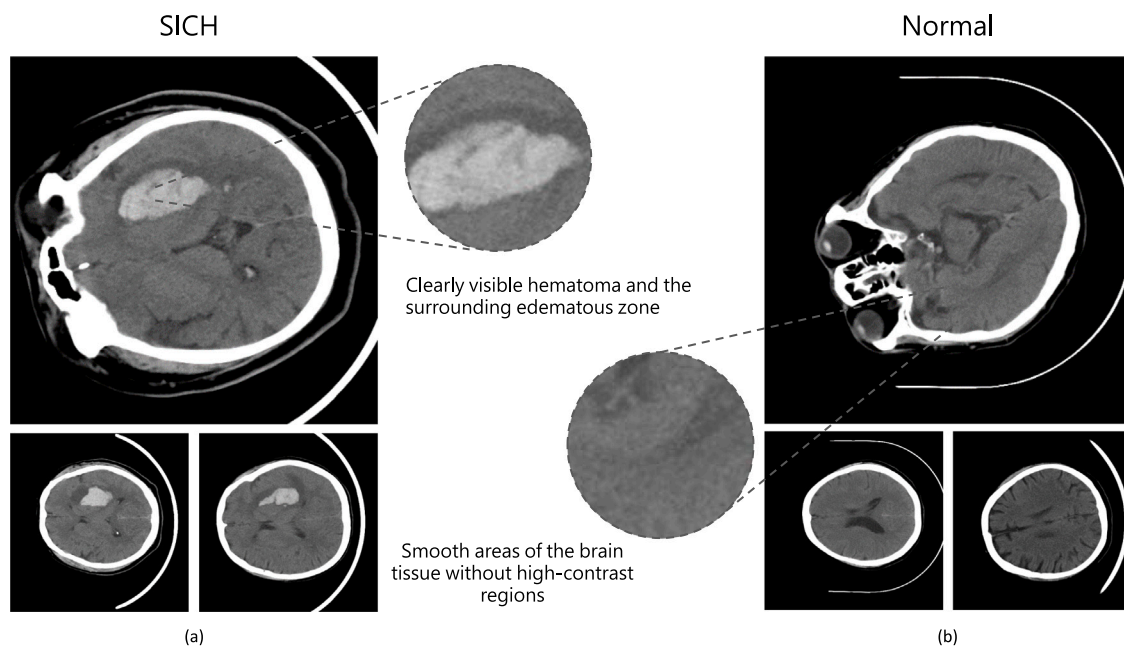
Example of CT images: (a) CT images of spontaneous intracerebral hemorrhage (SICH), (b) normal CT images without SICH. CT slices of SICH show evident hemorrhagic areas and surrounding edematous zones, while normal CT slices appear smooth and without anomalies.
